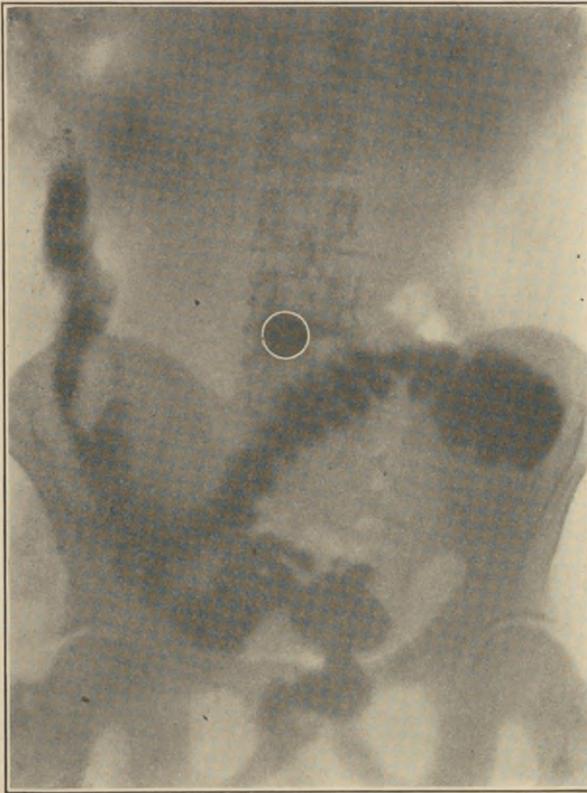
X-RAY PICTURE OF SAME SUBJECT SHOWN IN FIG. 138, TAKEN TWENTY-TWO HOURS AFTER BISMUTH MEAL.
